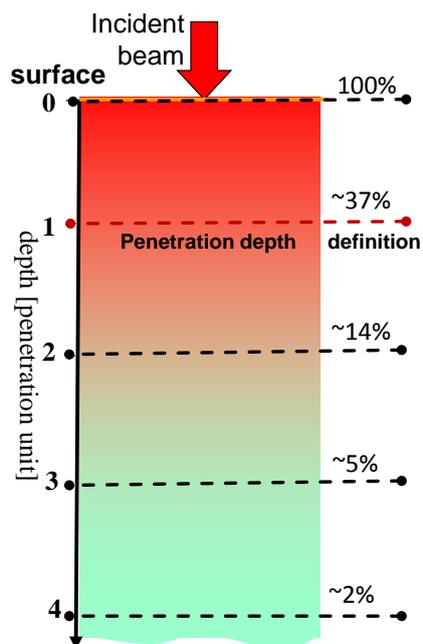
The principle of the definition of penetration depth: when the energy loss is 63% (remains 37%). Four times of penetration-depth, about 2% of the energy of the incident beam remains. This is the basis of X-ray diagnostic detection.
